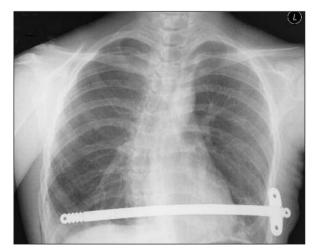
Posteroanterior x-ray five days after the second operation. A nonabsorbable stabilizer is visible on the left.
